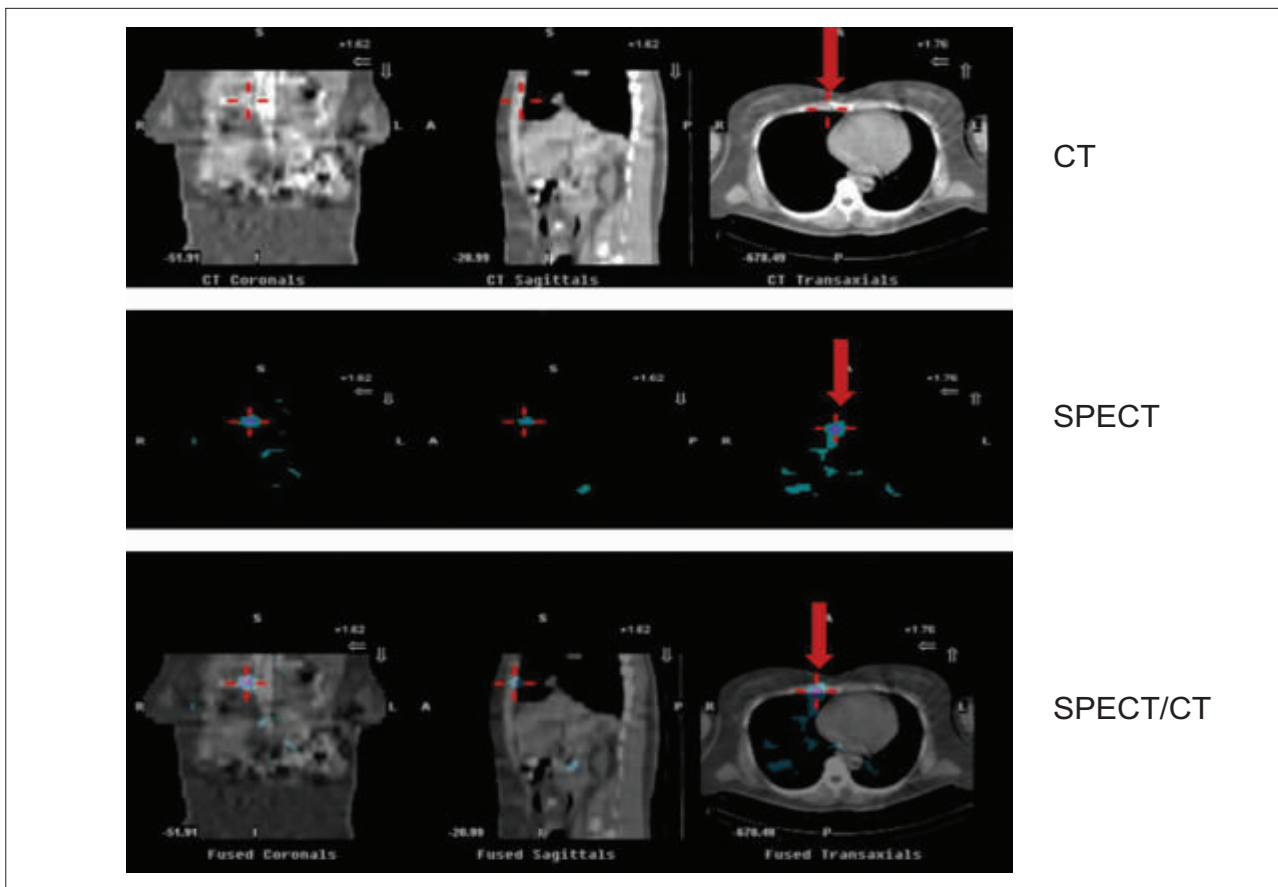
SPECT/CT scans of the chest in the same patient as in Figure-1 localizes the small thoracic lesion in the right lung close to the anterior chest wall (Red arrow).
